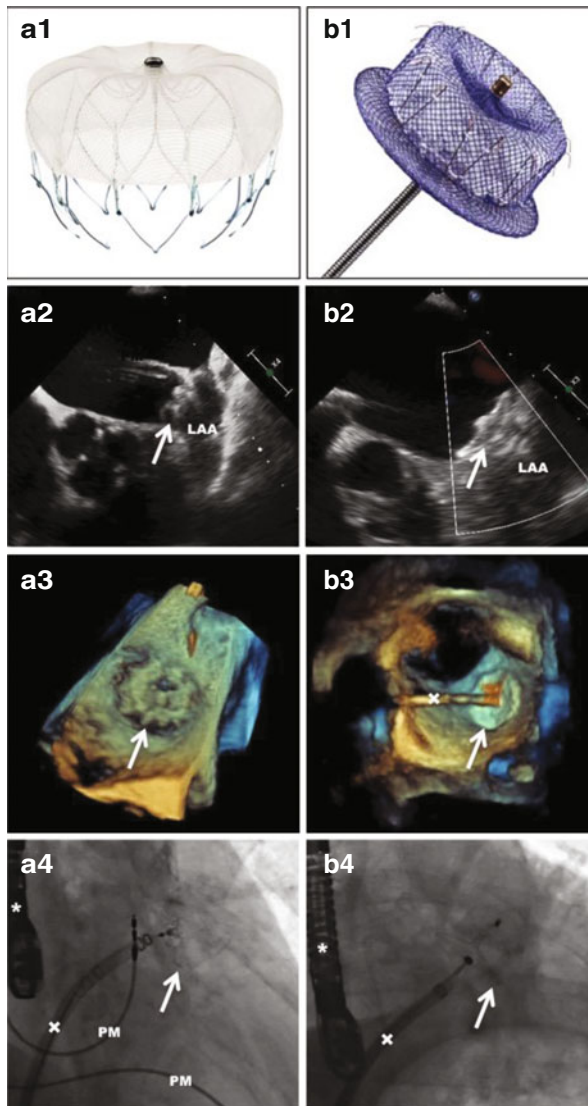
Panel (a1) shows the Watchman device (Boston Scientific), and Panel (b1) shows the Amplatzer Cardiac Plug 2 (ACP 2 or Amulet™, St. Jude Medical). Below are images of two patients who received the respective LAA occluder because of contraindications for long-term oral anticoagulation: 2D transoesophageal echocardiography (Panels a2 and b2), 3D transoesophageal echocardiography (Panels a3 and b3) and fluoroscopy (Panels a4 and b4). The occluder is marked by an *arrow*. * TEE probe; × delivery system; LAA left atrial appendage; PM pacemaker leads
